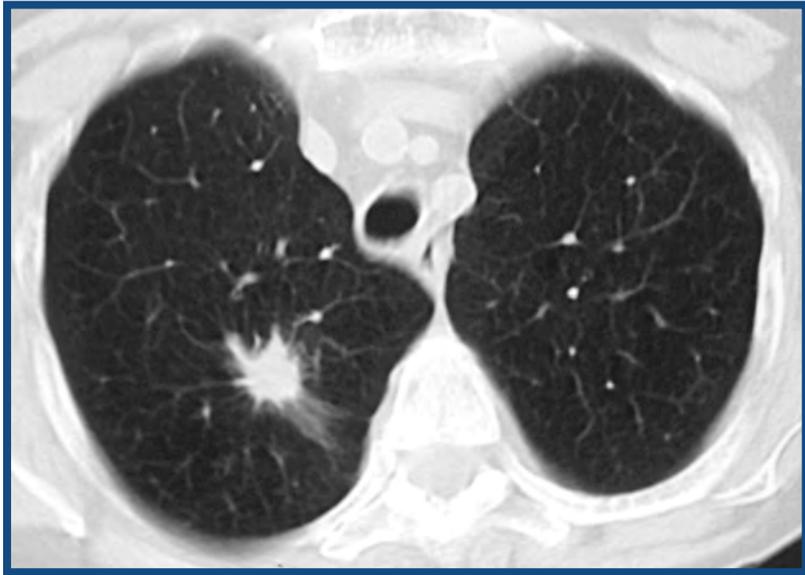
Spiculated lesion on CT highly suggestive of malignancy.
